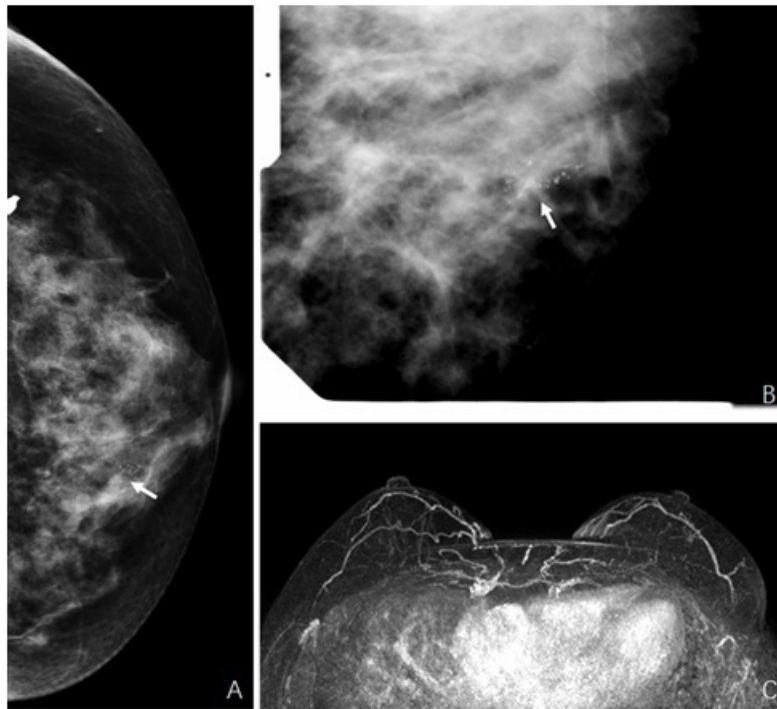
A 63-year-old female with a palpable mass in the left breast underwent diagnostic mammography and was detected with segmental fine pleomorphic calcification in the inner region of the left breast (A. craniocaudal projection and B. spot compression image, arrow) which was categorized as MG-BI-RADS 4C. The MIP image (C) derived from subtracted images of breast MRI found no abnormal enhancement at the indexed region and the patient was categorized as MRI-BI-RADS 1. Hook-wire localization and open-surgical biopsy of the microcalcification was performed for this patient. The final pathological analysis confirmed adenosis.
